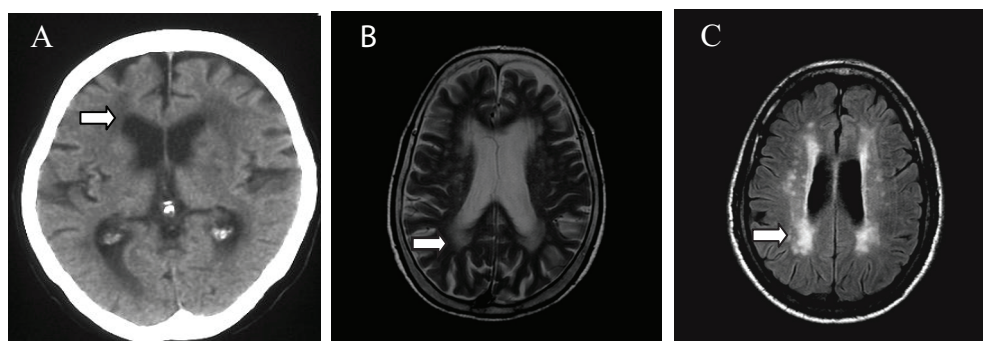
White matter changes on CT and MRI. A: hypodensity on CT; B and, C: hyperintensity on T2-weighted MRI and FLAIR sequence, respectively.
